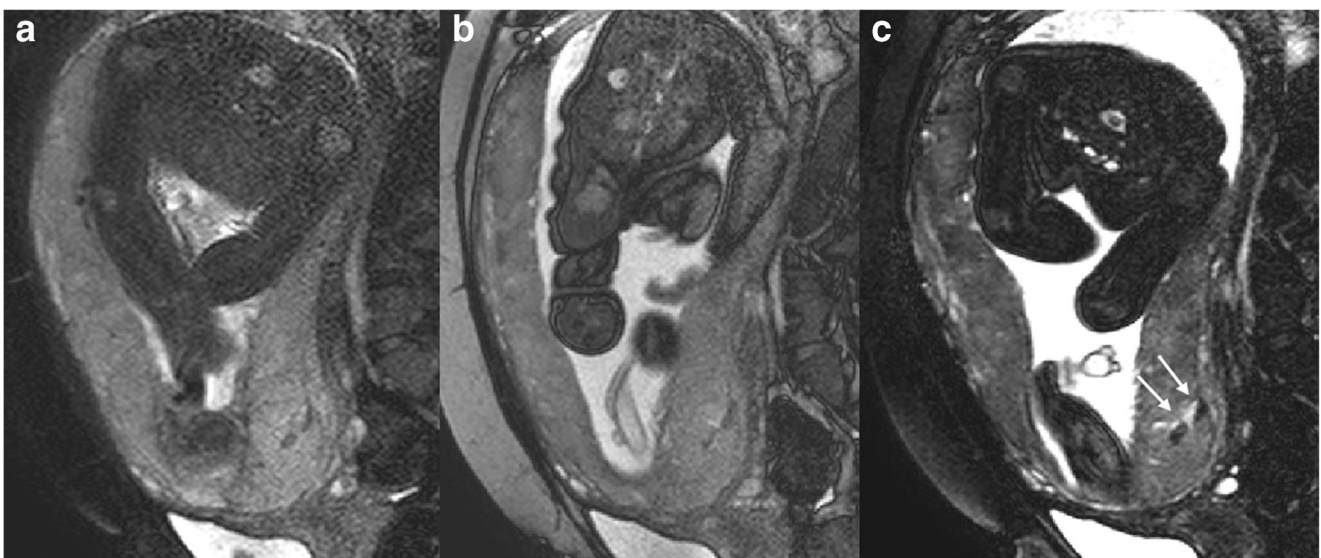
Representative case of confirmed placenta accreta vera, showing DIB with different MRI sequences. a SSFSE; b same layer in b-SSFP; c same layer in T2W b-SSFP. Note that the low signal band is most pronounced in the T2W b-SSFP (arrow)
